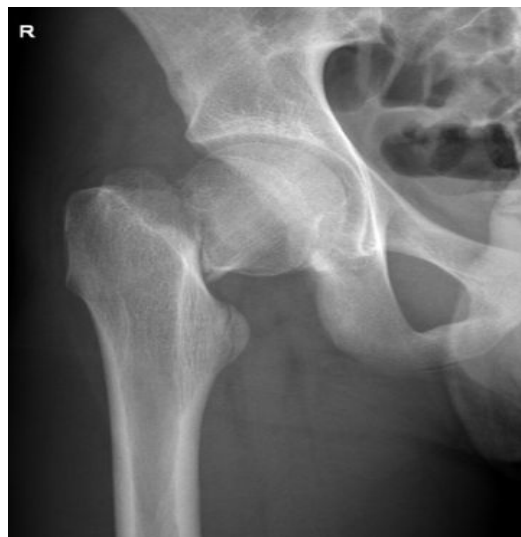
AP radiograph of the right hip showing a displaced transcervical femoral fracture with a vertical fracture line of about 70° (AO31B2.1 or Delbet II, respectively).
